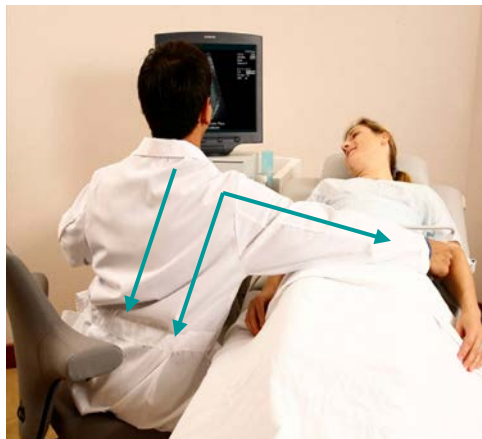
The sonographer's chair is too low for the height of the ultrasound monitor. The patient is positioned too far from the sonographer causing him to twist his trunk and abduct his arm 90° from his body in order to reach the patient.
